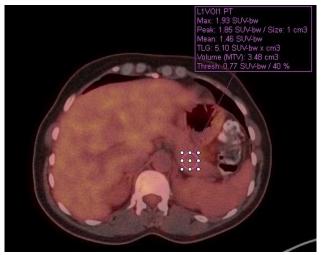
Calculation of the SUVmax and SUVmean from the endocrine organs using circular region of interest
